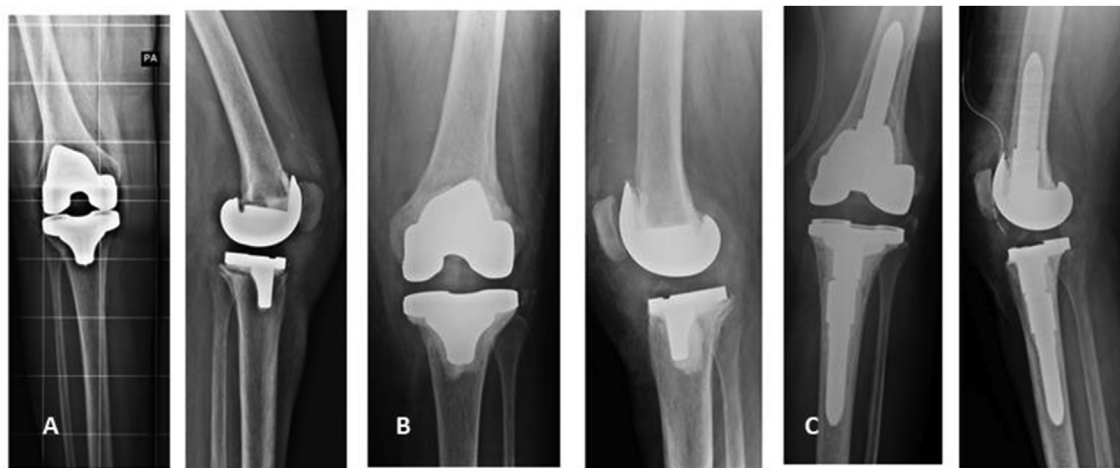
A: Plain radiographs of patient with *S. Aureus* MRSA infection before surgery, B: Plain radiographs after Hoffman Technique, C: Plain radiographs at second stage revision.
